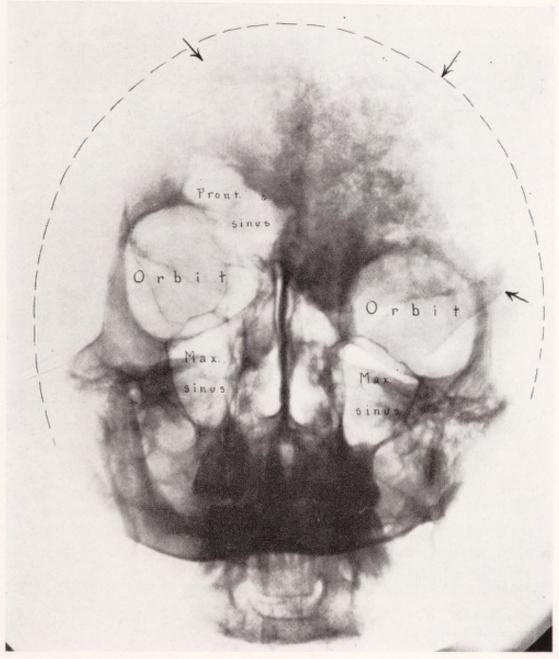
Case 25. X-ray of diffuse osteoma (cf. Figs. 2 and 3), which has obliterated right frontal sinus. Entire right orbit is placed lower than the left. The antrum is also lower, almost suggesting a congenital displacement of these cavities.
